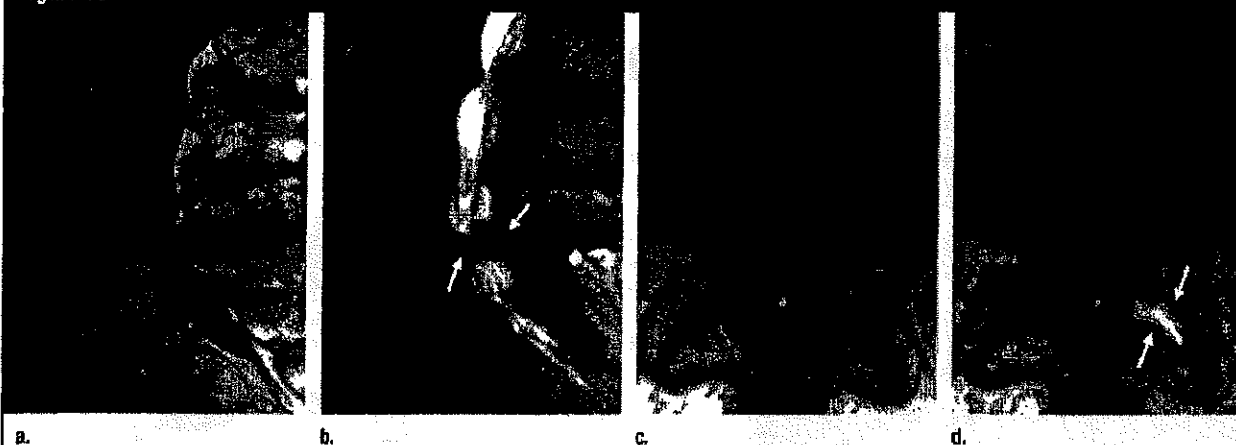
Spinal stenosis. Sagittal (a) T1-weighted SE (450/15) and (b) T2-weighted fast SE (4000/120) images through lower lumbar spine. There is grade I degenerative spondylolisthesis at L4-5, thickening of the ligaments posteriorly, and severe stenosis of central canal (arrows). Transverse (c) T1-weighted (450/15) and (d) T2-weighted fast SE (4000/120) images through L4-5 disk space show severe bilateral degenerative facet changes with distraction and fluid in the left joint (arrows). There is severe central canal stenosis and thickening of posterior ligaments.
